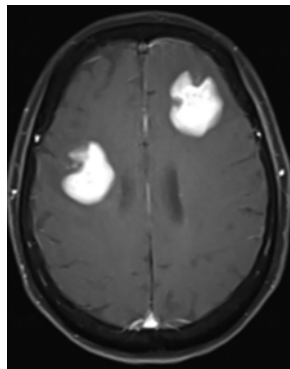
Brain MRI with more relapsed progressed primary central nervous system lymphoma. Brain MRI showed rapid 4th progression on post-contrast T1 image after a clinical trial therapy, at 23 months since diagnosis.
